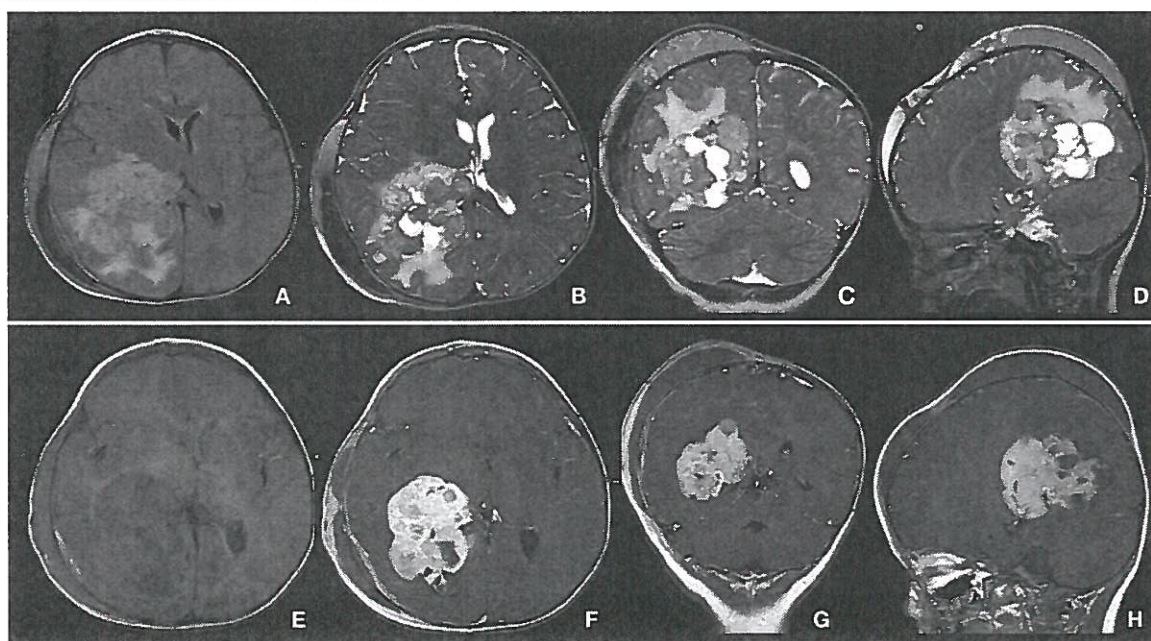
Choroid plexus carcinoma of right ventricle, in 2-year-old girl with Turner syndrome, polycystic kidney, nephrolithiasis, and posttraumatic skull fracture with cephalohematoma over right hemisphere. Technique: head coil, 1.5 T, gadobutrol 1 mL by manual injection. Protocol: FLAIR, T2 TSE, T1, T1 Gd. Slice thickness 3–4 mm. Findings: Pre-contrast T2-weighted (B, C, D) and FLAIR (A) images showed a brain tumor with inhomogeneous signal in right ventricle. Surrounding parenchyma of the right hemisphere showed bright signal in T2. Post-contrast (F, G, H): inhomogeneous enhancement in the tumor with cystic changes compared with pre-contrast images (E). Conclusions: MRI provided differential diagnosis of plexus carcinoma vs. plexus papilloma. Courtesy Dr G Hahn.
